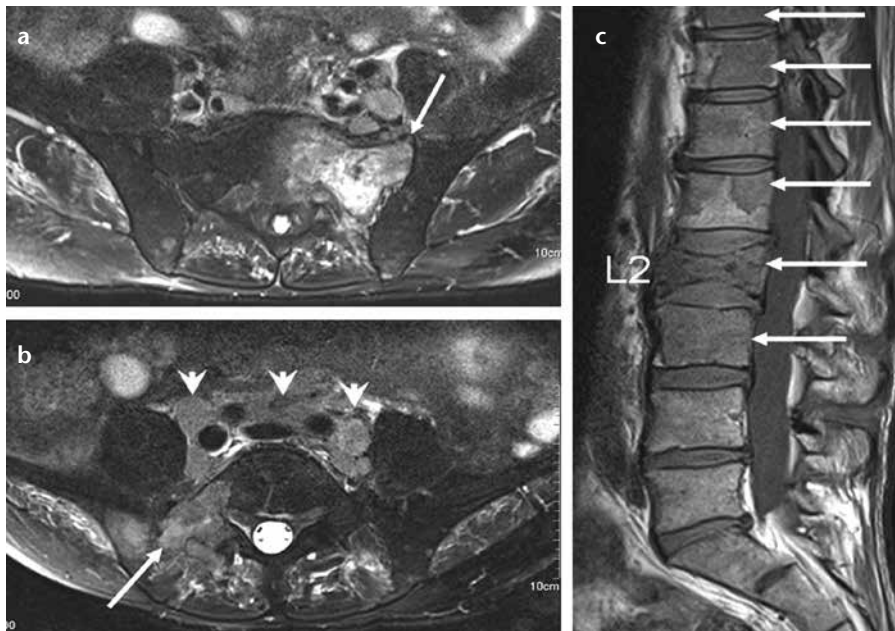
a-c. A 57-year-old male who was diagnosed with diffuse large B-cell lymphoma with bone marrow infiltration following a biopsy. The axial fat-saturated T2-weighted image (a) shows a fracture in the left sacrum (arrow) and surrounding diffuse hyperintensity. The hyperintensity on the MRI alone can indicate reactive edema or malignant bone marrow infiltration. In this patient, it was thought to be a pathological fracture at the site of lymphomatous infiltration because of the absence of a history of trauma and the known widespread bone marrow infiltration. Additional diffusion-weighted MRI would have helped to distinguish between benign and malignant fractures: hyperintensity in both low b and high b value images with low ADC values would have confirmed malignant infiltration, as shown in Fig. 1. The axial fat-saturated T2-weighted image at a different level (b) shows a malignant mass (arrow). Also note the perivascular lymph node enlargement (arrowheads). The sagittal T1-weighted image (c) shows abnormal hypointensity in the T9–11 and L1–3 vertebrae (arrows) and a compression fracture of the L2 body. This fracture was also considered to be a pathological fracture.
